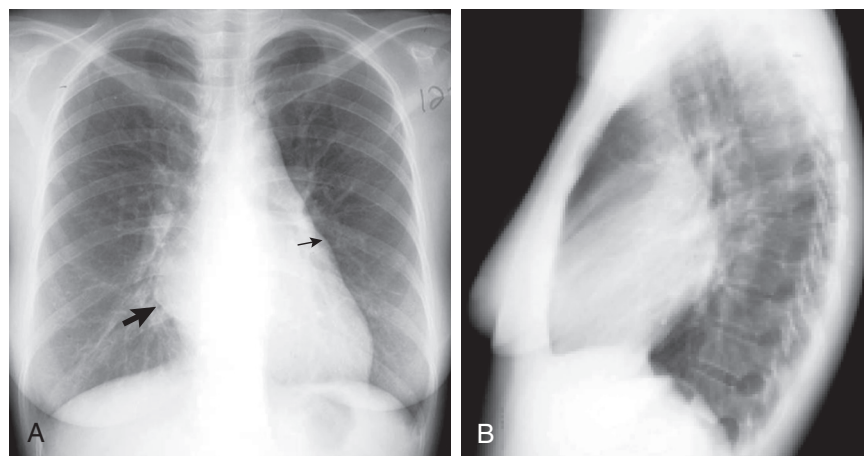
FIGURE e15-8 Chest radiographs of a 39-year-old Asian woman with rheumatic mitral stenosis. A, Frontal view showing normal heart size, mild vascular redistribution, and marked focal enlargement of the left atrium (*small arrow*), which extends to the right of midline (*large arrow*). There is elevation of the left main stem bronchus. B, Lateral view showing a dilated right ventricle with filling in of the retrosternal airspace. The left ventricle is normal in size and contour.
